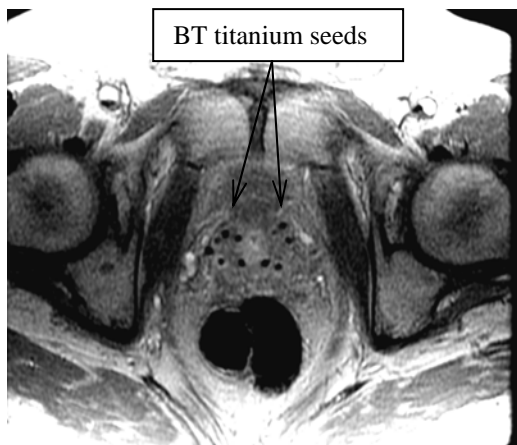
Post-implant axial T1-weighted images of the prostate (Base) with MRI (1.5 T).
